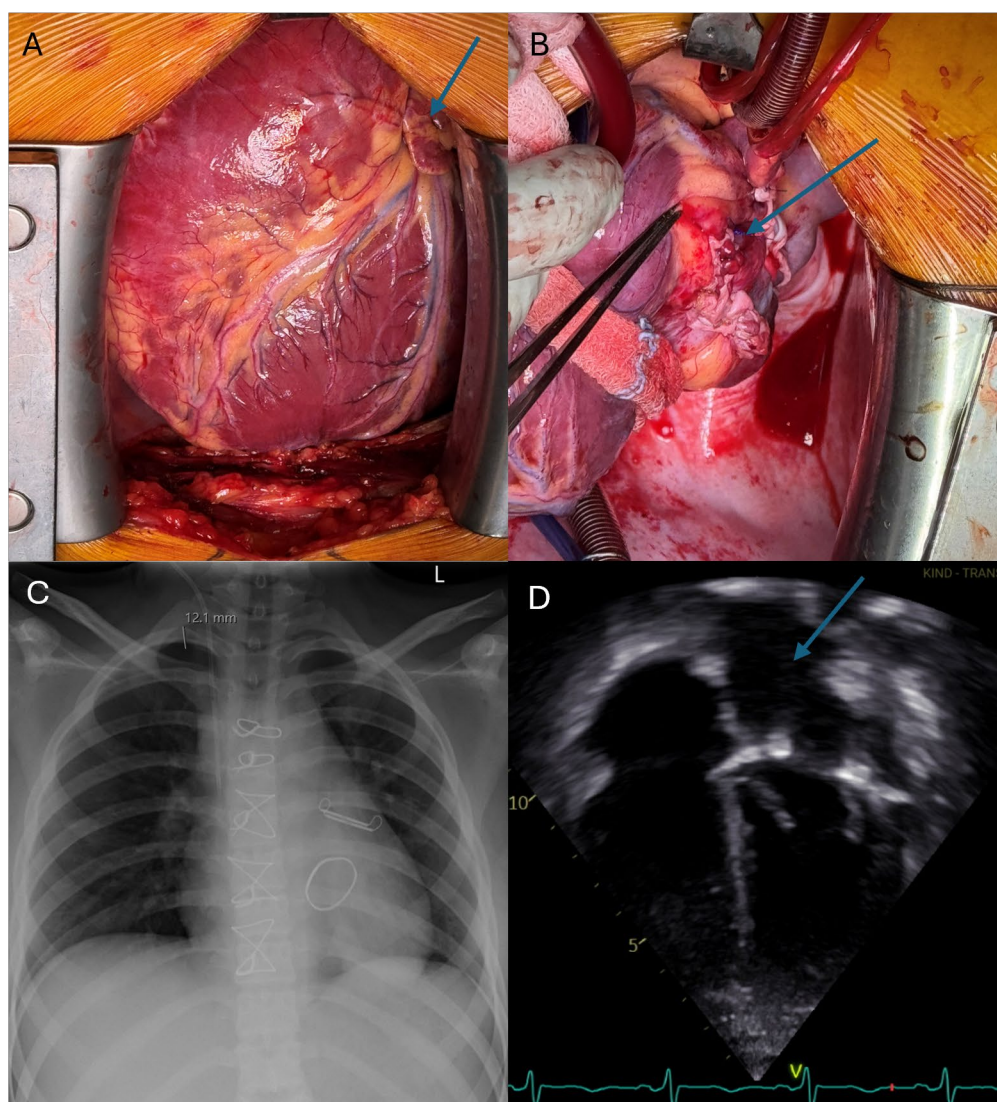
Intra- and postoperative images: (A) intraoperative view prior to surgical correction with dextrorotation of the heart and arrow towards left atrium, (B) intraoperative view after left atrial reduction plasty with arrow to plicated left atrium, (C) postoperative chest x-ray p.a. view, (D) transthoracic echocardiographic four-chamber view with arrow to the left atrium.
